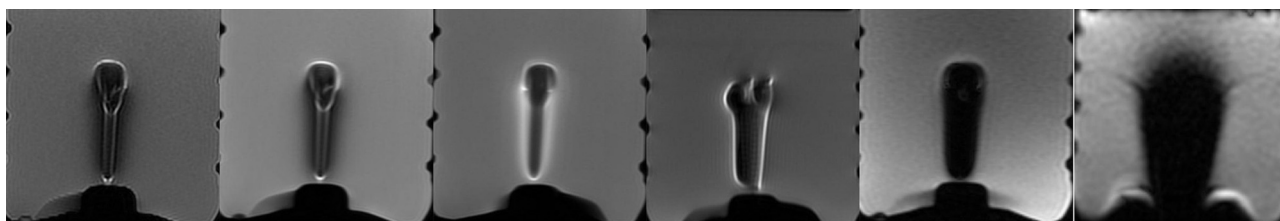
(a–f):T1-FSE, T2-FSE, STIR, T2-FSE-FS, GRE, DWI. MR images showed artifacts appeared as voids or geometric distortions. Section location oriented to the long axis of the screw and the slice was selected with largest artifacts.
